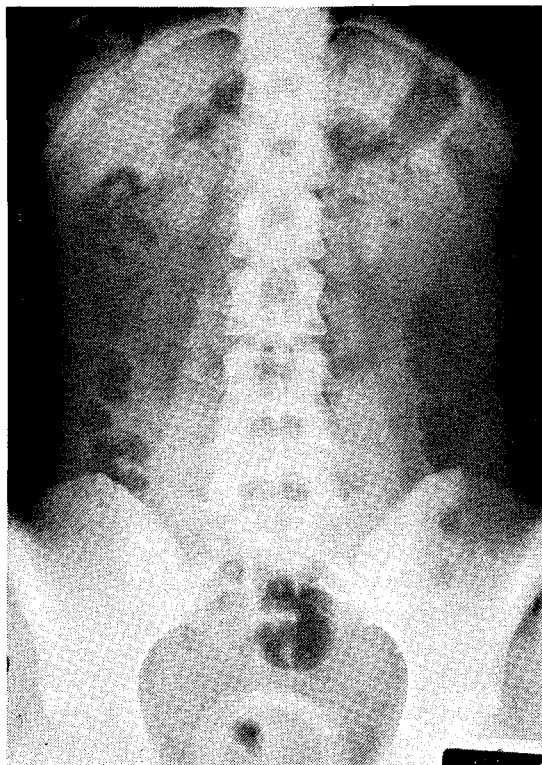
KUB radiograph showing foreign body.
